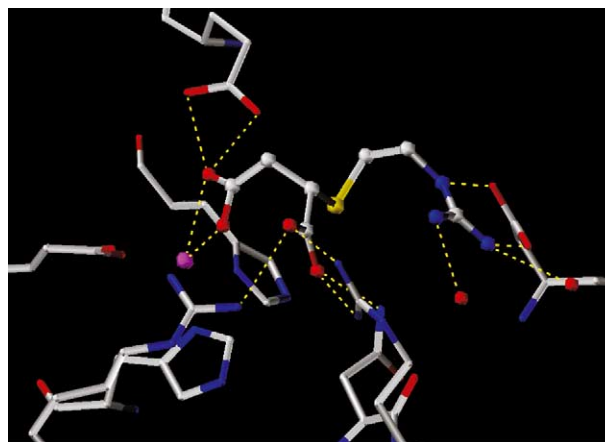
X-ray structure of compound 2 in complex with CPB. Zinc atom in magenta, water molecules in red and hydrogen bonds in dotted yellow lines.
